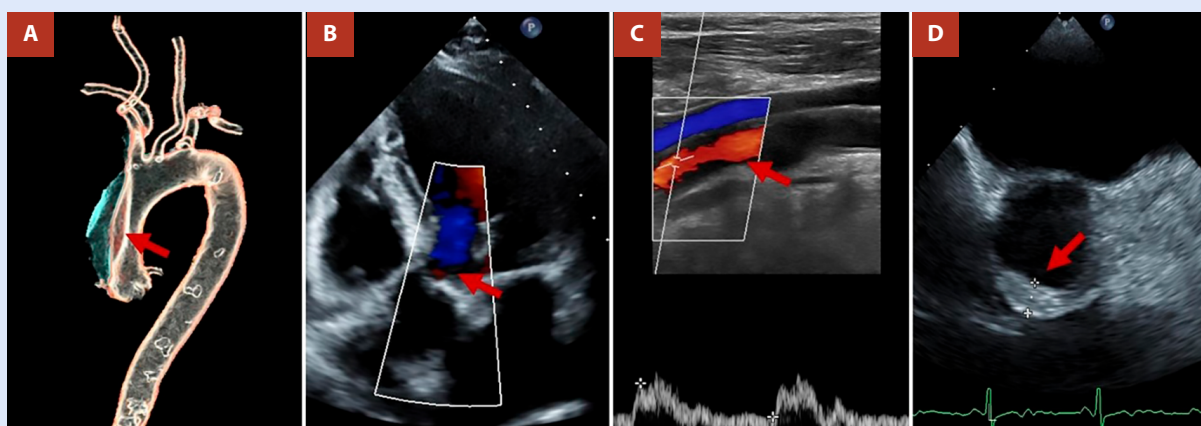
A. Three-dimensional reconstruction of aortic computed tomography angiography (CTA), showing the ascending aortic dissection (red arrow) terminating before the origin of the left subclavian artery. B. Transthoracic echocardiography demonstrating absence of significant aortic valve disease and no evidence of pericardial effusion. C. Carotid ultrasound showing no impairment of flow in the right carotid artery. D. Transoesophageal echocardiography demonstrating an intramural haematoma in the ascending aorta, without signs of progression of the dissection.
